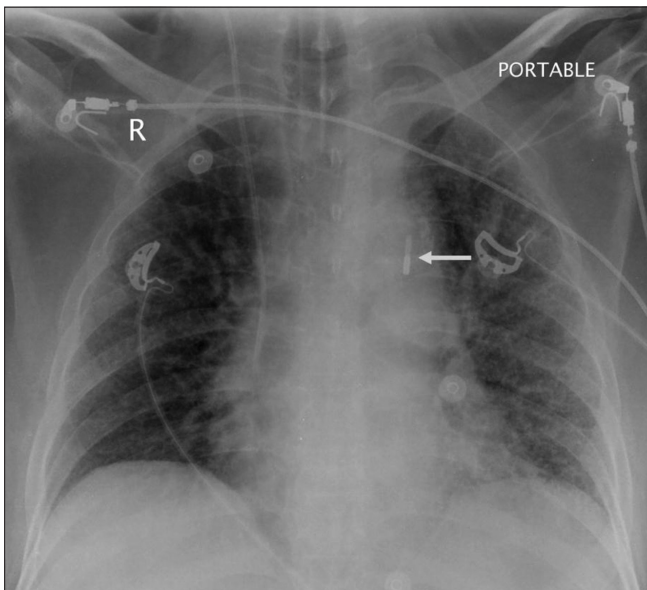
Frontal chest radiograph demonstrates an optimally positioned intra-aortic balloon pump catheter. The catheter tip is identified by a rectangular metallic density (arrow)
